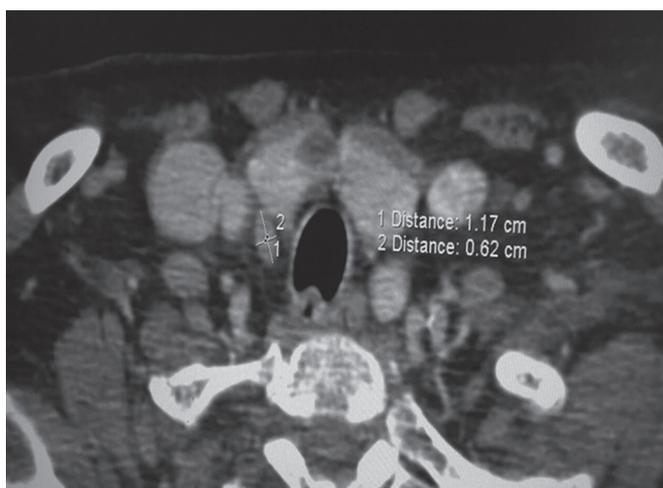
Axial contrast-enhanced computed tomography scan – lesion of 1.17 × 0.62 cm at the inferior pole of right lobe thyroid
